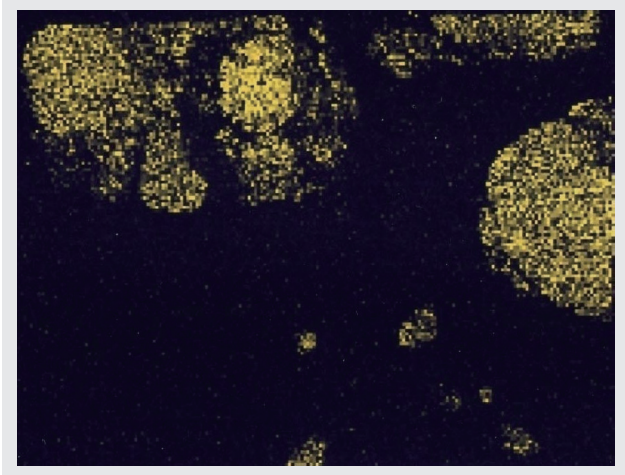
Ca K fluorescent X-ray image
